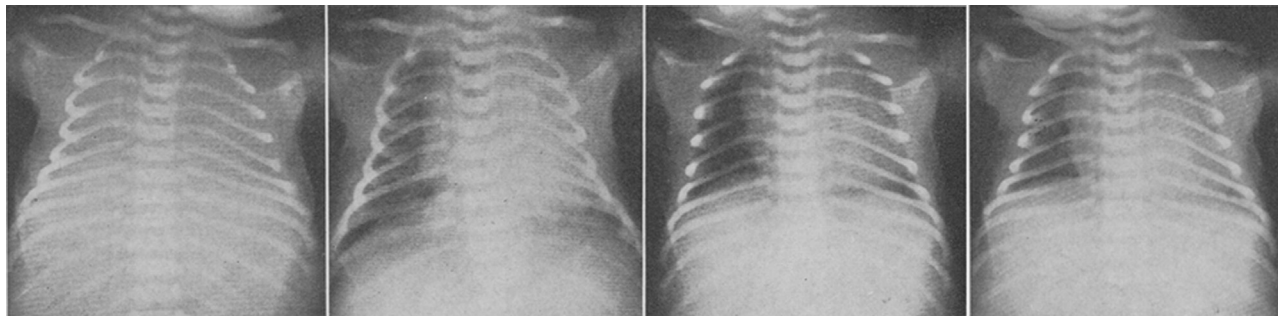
X-ray of aeration of the lungs during the first breaths of a term born infant [23].
